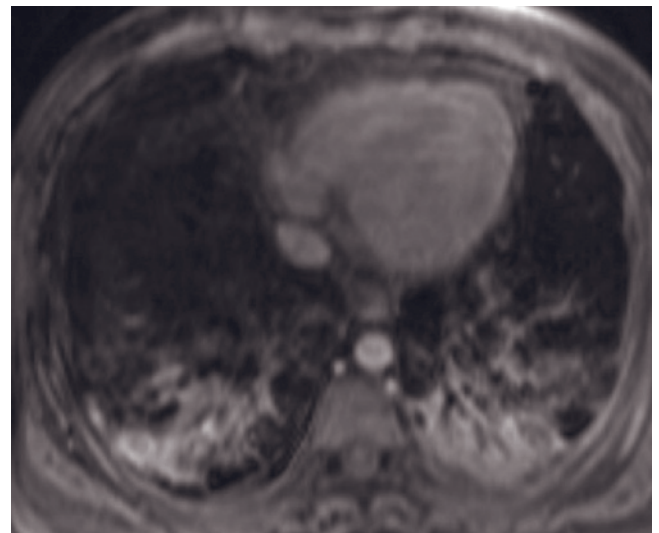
(Continued) T1-weighted fat-suppressed postgadolinium 3D-GE (n) images demonstrate lymphangitic spread in the right lung in patient 7 with lung cancer. Coronal T2-weighted single-shot echo-train spin-echo (o), transverse T2-weighted fat-suppressed single-shot echo-train spin-echo (p), and transverse T1-weighted postgadolinium fat-suppressed 3D-GE (q, r) images demonstrate a consolidation (arrows, o-q) in the left lung in patient 8 with AIDS and disseminated *Cryptococcus neoformans* infection. There is minimal left pleural effusion seen as high signal intensity adjacent to the aorta. Note that there are multiple infectious foci seen as low-signal-intensity structures (arrow) in the spleen on postgadolinium image (r).
